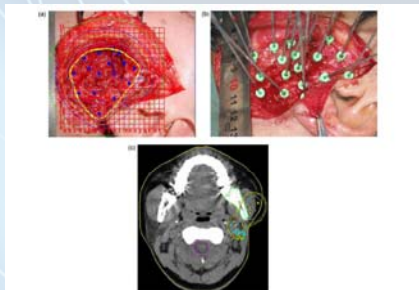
(a) Intraoperative view for ¹²⁵I seeds, based on radiological confirmation. The yellow line is the target area. (b) Seeds implanted. (c) CT verification of the dose and seed position. The yellow dot shows the seed and the red line is the 90% dose isodose line.
